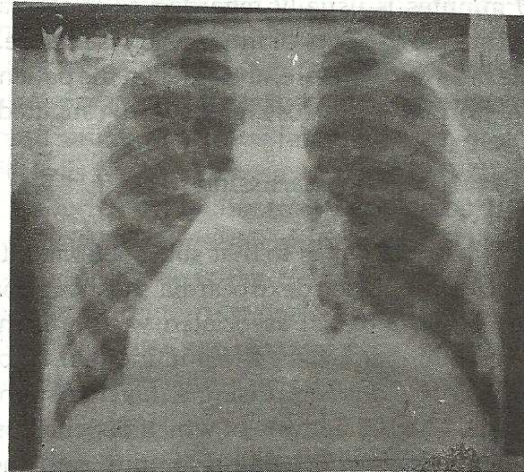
Chest radiograph (PA view) of the patient at the age of 10 years showing no obvious changes from the initial one.
